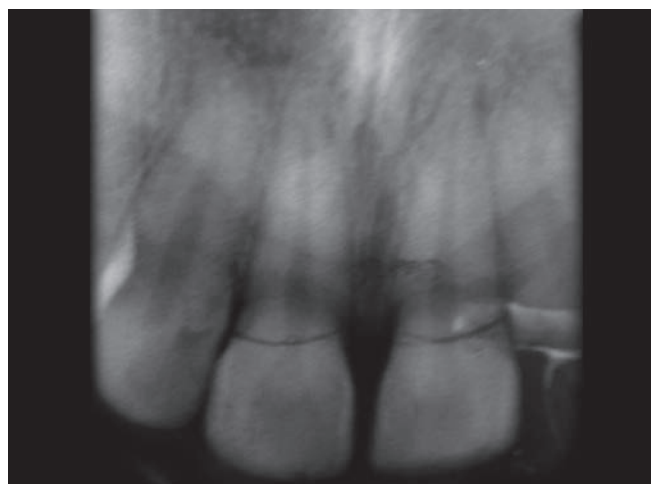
Intraoral periapical showing oblique fracture labiopalatally
